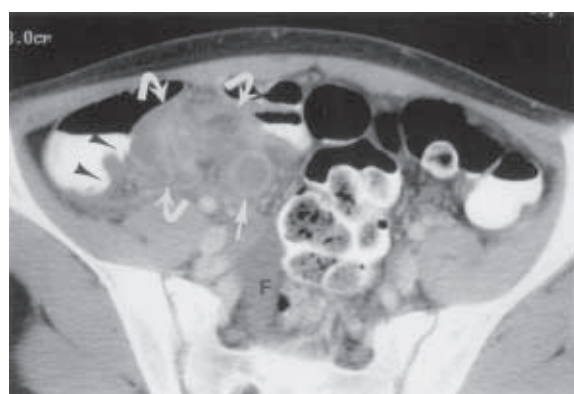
Appendicitis with perforation. Although this CT does not show specific findings for perforation, the degree of inflammatory changes (phlegmon, curved arrows) are substantial and suggest perforation. Arrow = enlarged appendix. Arrowheads = medial cecal wall thickening. F = fluid.
